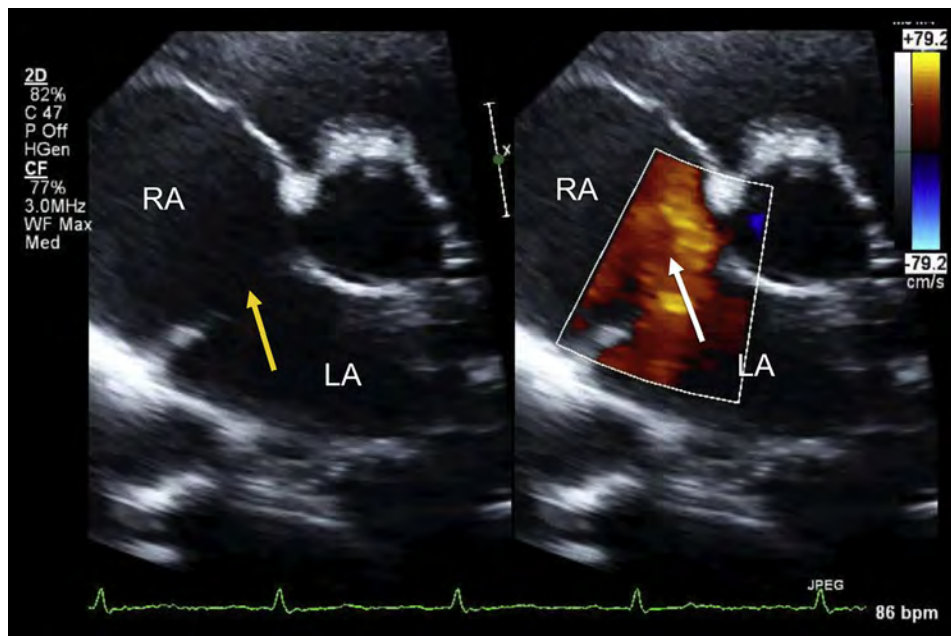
TTE of a secundum type ASD in the parasternal short-axis view without and with color Doppler in pediatric patient. See also Video 14.
